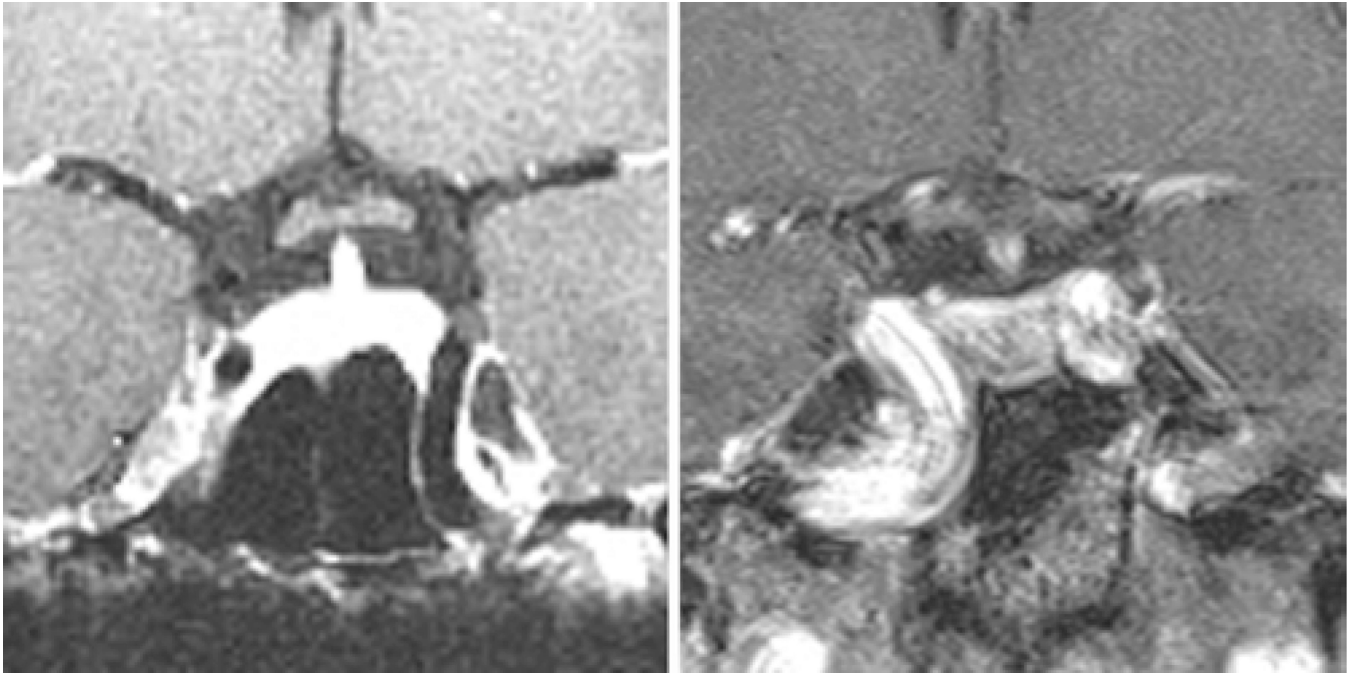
Coronal, postcontrast MR images obtained in 2 patients with prominent ICA projection into the sphenoid sinus (present in 4%–10% of patients), warranting additional caution during the sphenoid phase of a transsphenoidal operation.
